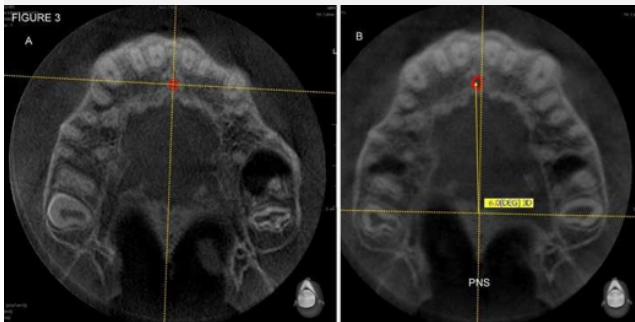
The amount of incisive foramen displacement was calculated by measuring the angle of the linear line drawn by the spinal nasalis posteriorly from the center of the incisive foramen.a) Preoperative CBCT view of the linear angle incisive foramen's center makes with PNS b) CBCT view that shows postoperative transposition of incisive foramen
